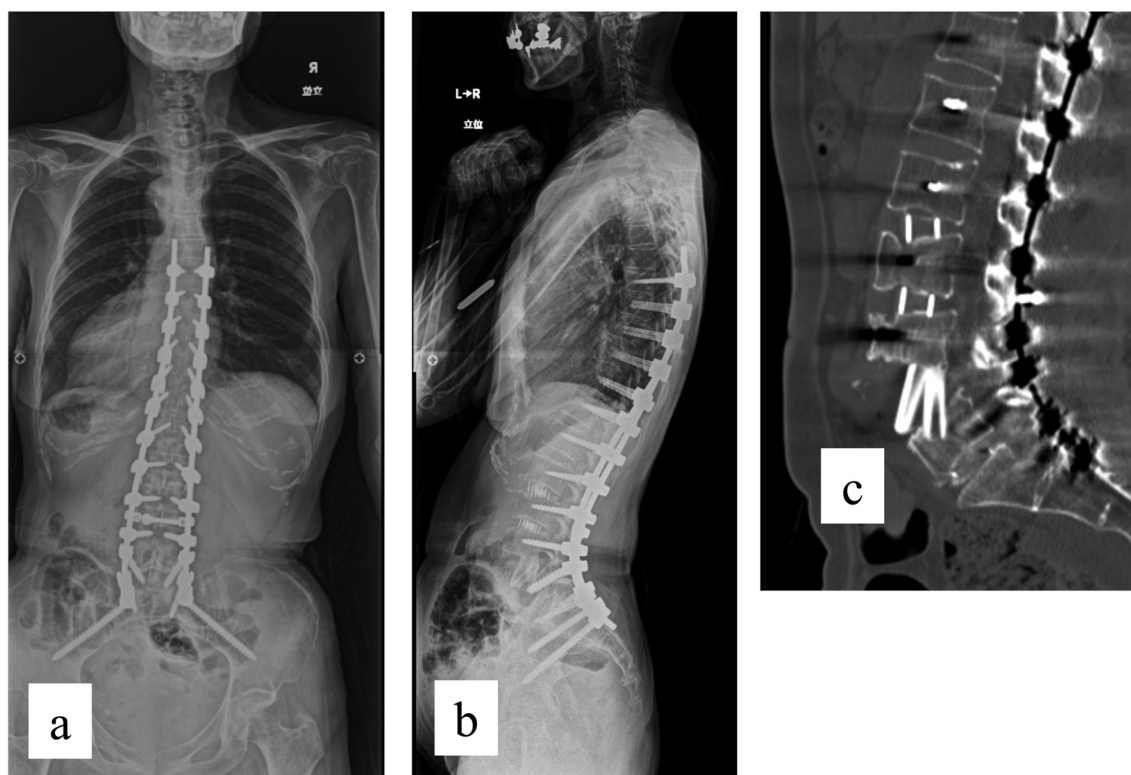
Postoperative whole-spine radiographs in the anteroposterior (a) and lateral views (b) views. (c) Postoperative sagittal CT images of the fibular graft implanted in L4/L5.
